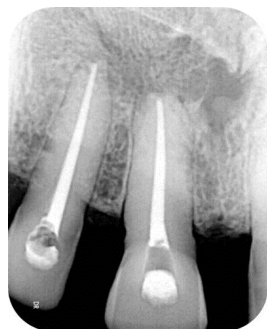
Signs of bone formation on periapical radiograph after 6 months of follow-up
